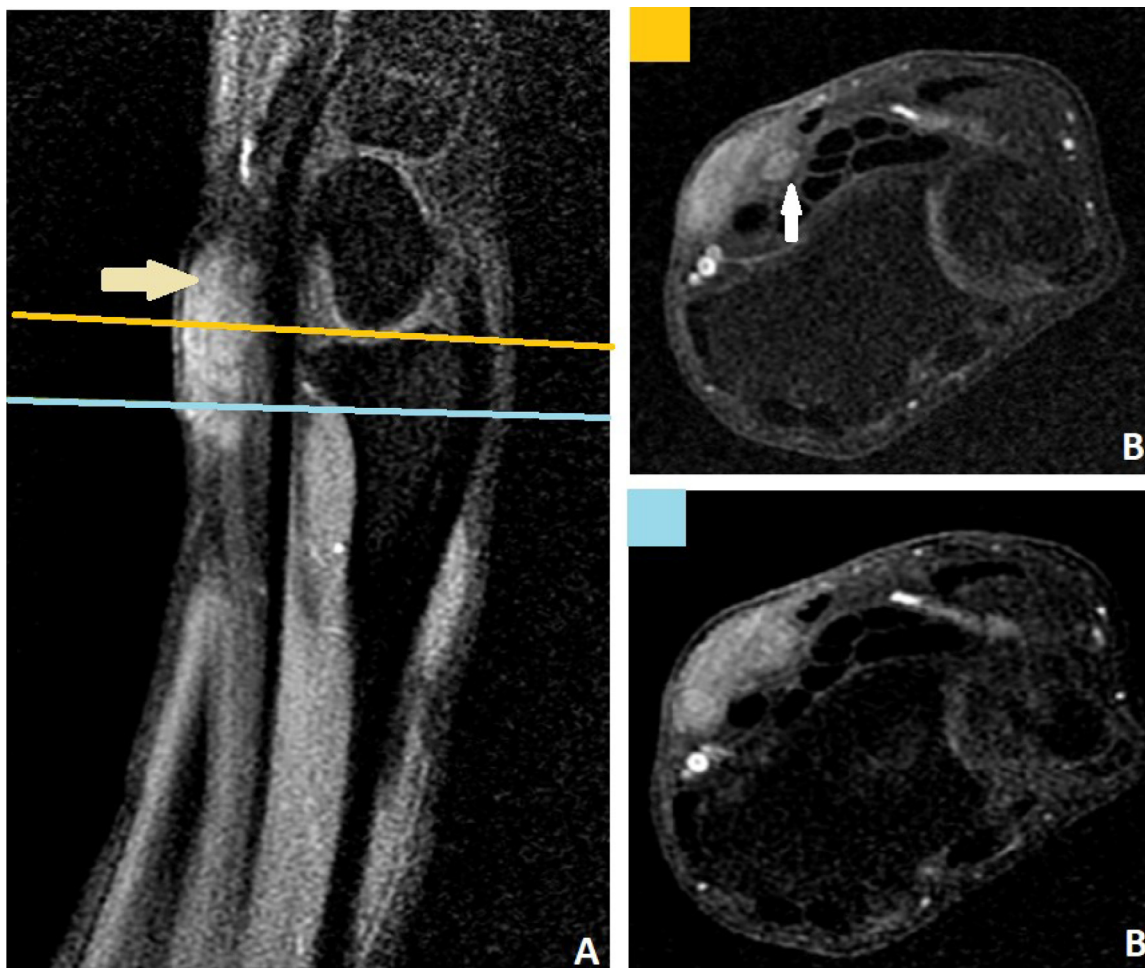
T1-weighted image fat saturated and contrast enhanced in the sagittal plane (A) and the respect axial sections (B) showing:
